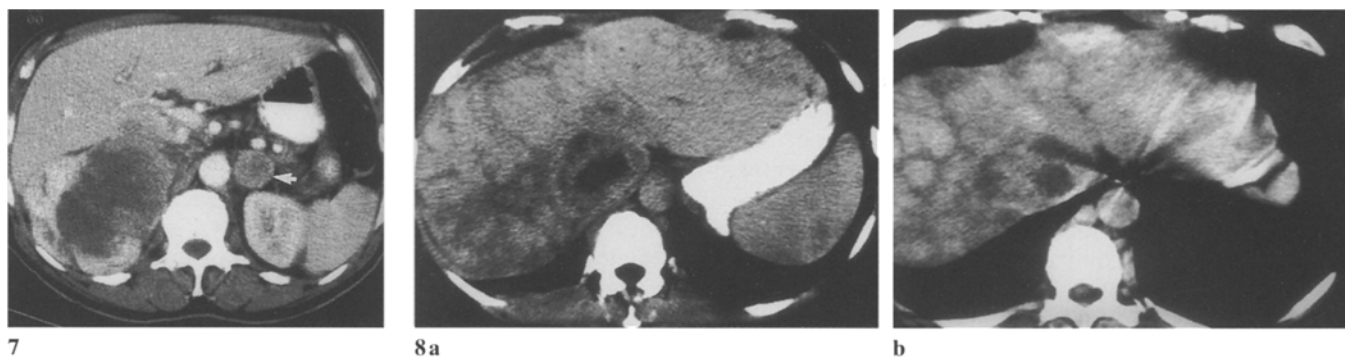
Stage IV renal cell carcinoma. Postcontrast CT scan showing a right-sided renal cell carcinoma extending directly into the IVC. There is a left-sided adrenal metastasis (*arrow*)
